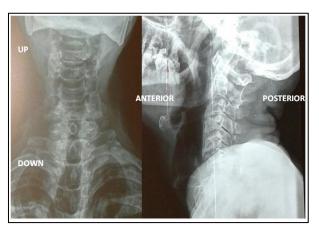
Cervical x-ray Face/Profile
